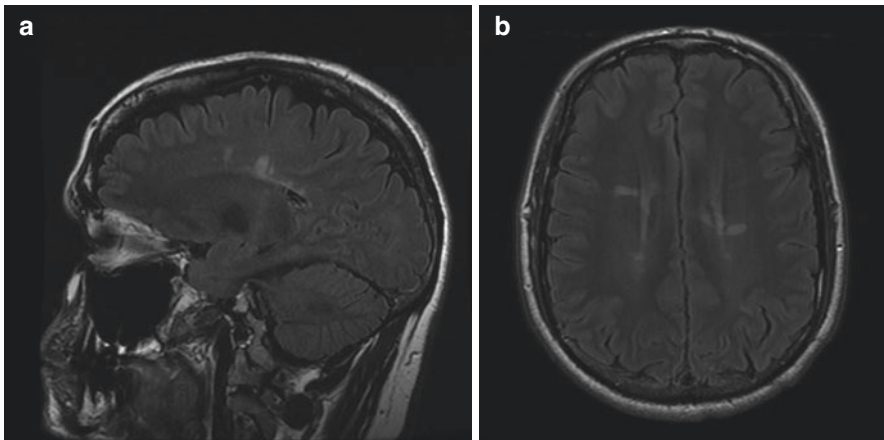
(a) Sagittal and (b) axial T2-weighted FLAIR MRI demonstrates typical distribution of periventricular white matter lesions in MS, oriented perpendicular to the lateral ventricles, and involvement of the corpus callosum (© AD Henderson 2021. All Rights Reserved)
